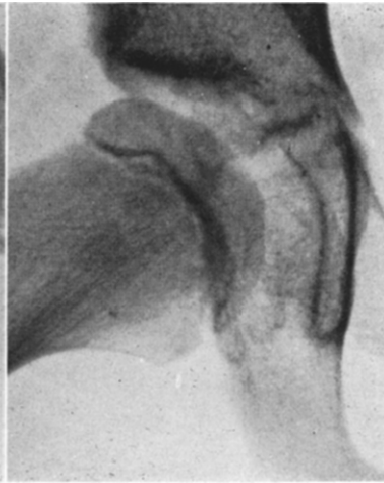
Case VI. Roentgenogram five years after drilling, February 10, 1940; well shaped and developed head and neck; normal bone structure.
